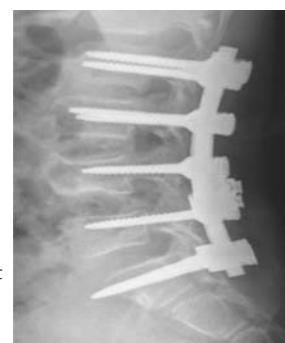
Postoperative non-contrast CT scan of LS spine of the patient shown in Fig 3 showing implants in situ with normal alignment
